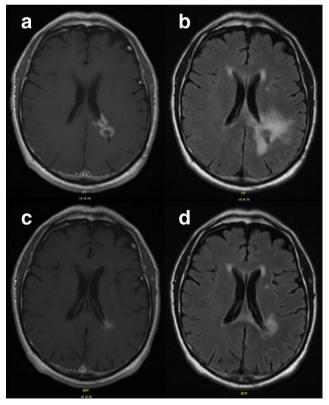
Radiographic response to bevacizumab. Magnetic resonance imaging of a patient with left parietal glioblastoma before (A, B) and after (C, D) bevacizumab. There is decreased enhancement (A, C) and decreased T2/FLAIR hyperintensity (B, D) two months after initiating treatment
